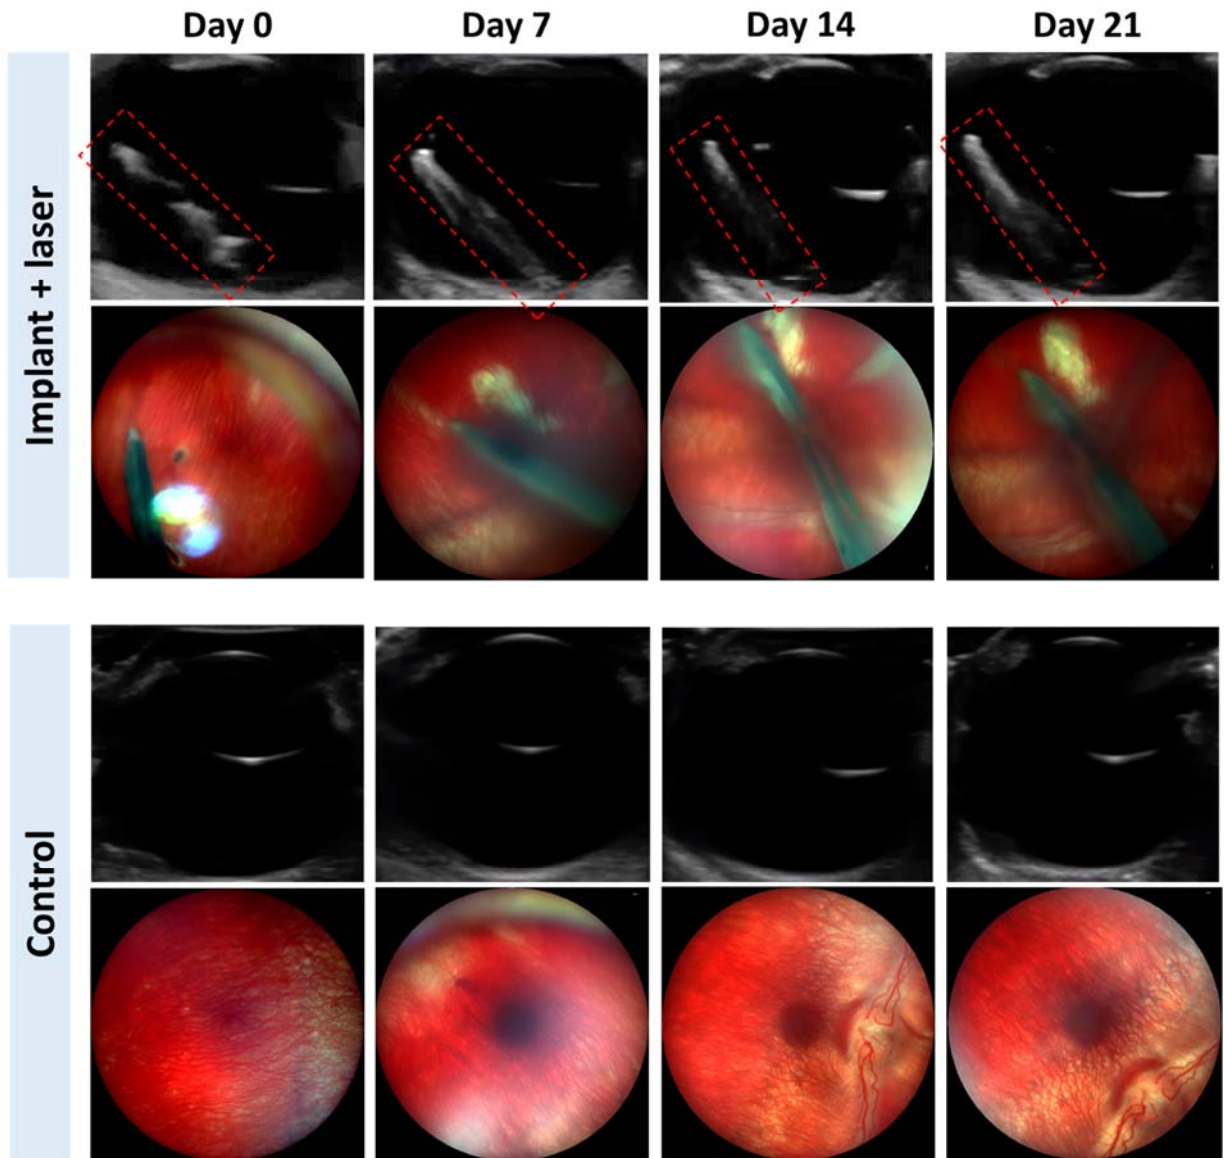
Ultrasound and optical images of the implant-injected eye showing the retina and the implant, and the control eye on Day 0, Day 7, Day14 and Day 21, respectively.
